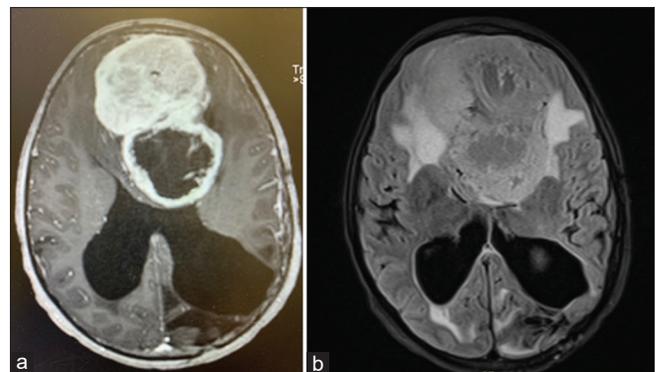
(a) Axial magnetic resonance imaging (MRI) with contrast showing tumor extending from anterior fossa to intraventricular space. (b) Axial MRI with fluid-attenuated inversion recovery sequence showing the significant perilesional edema.
